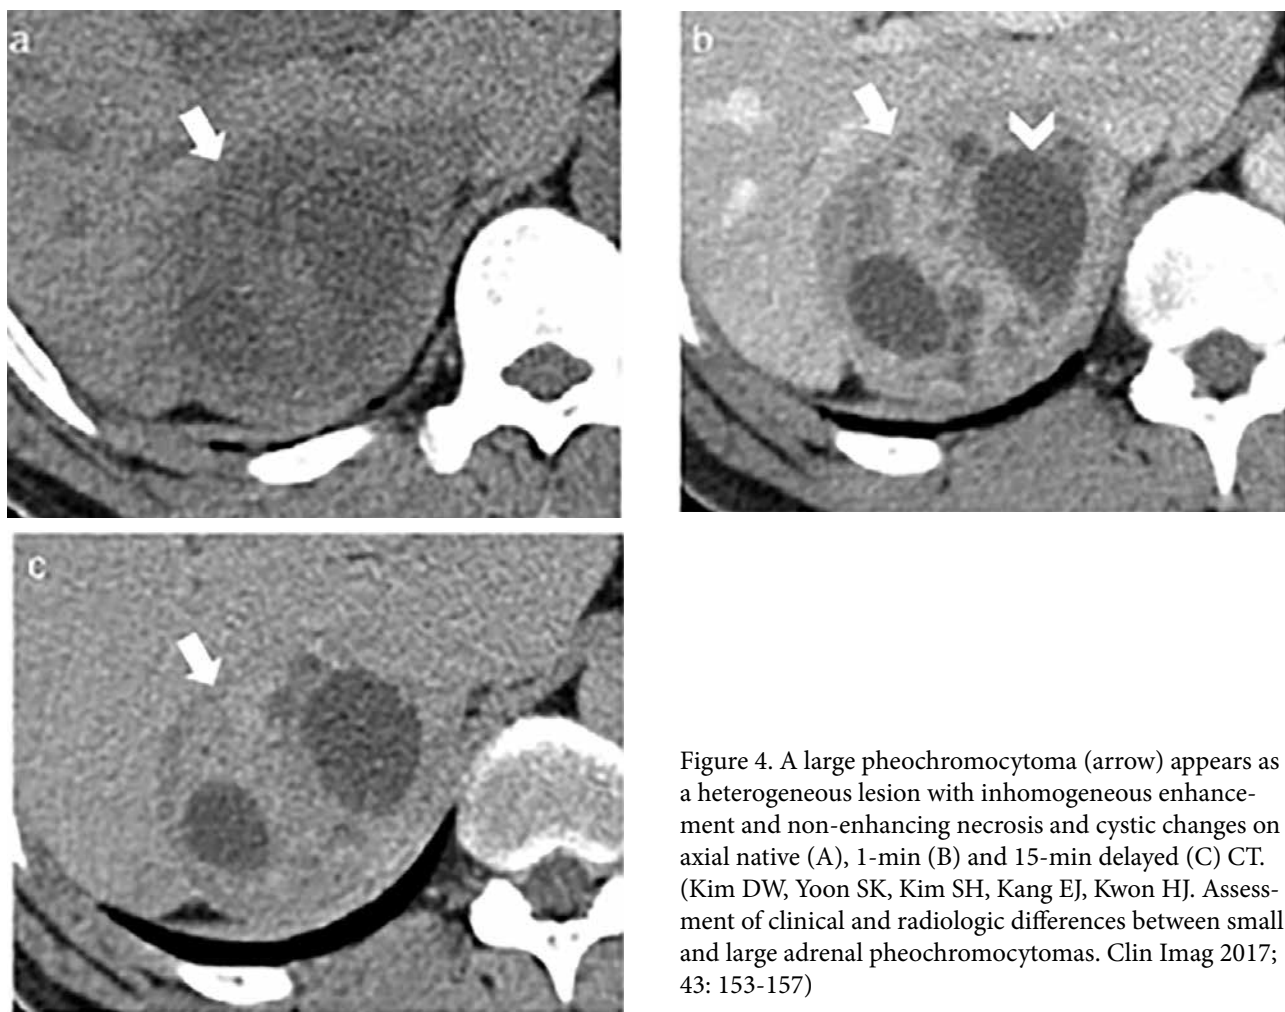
A large pheochromocytoma (arrow) appears as a heterogeneous lesion with inhomogeneous enhancement and non-enhancing necrosis and cystic changes on axial native (A), 1-min (B) and 15-min delayed (C) CT. (Kim DW, Yoon SK, Kim SH, Kang EJ, Kwon HJ. Assessment of clinical and radiologic differences between small and large adrenal pheochromocytomas. *Clin Imag* 2017; 43: 153-157)
